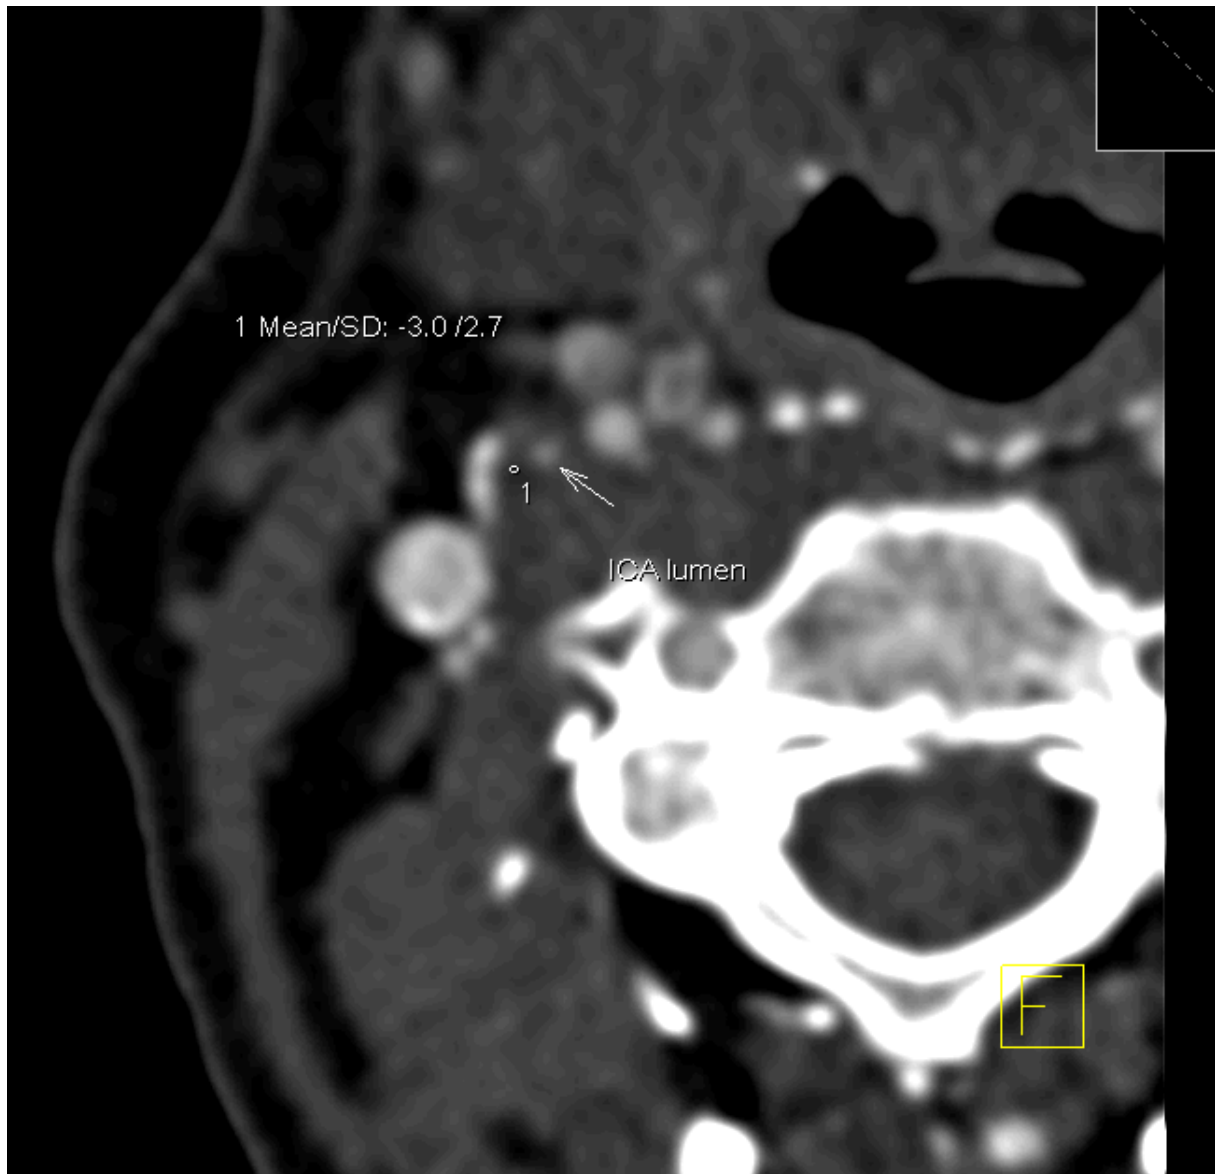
MDCT. Plaque with the least measured tissue density of -3 Hounsfield units (HU). ICA-internal carotid artery, MDCT- multidetector-row computed tomography.
